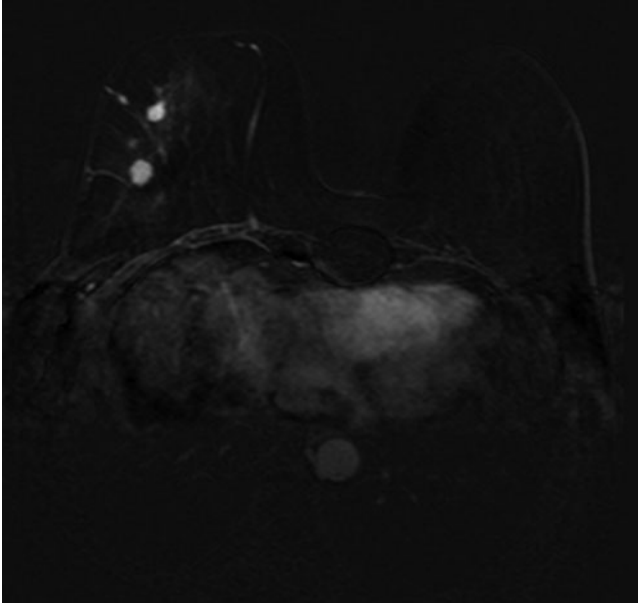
A 32-year-old female patient with breast carcinoma, MR image shows occult foci away from index invasive tumor
